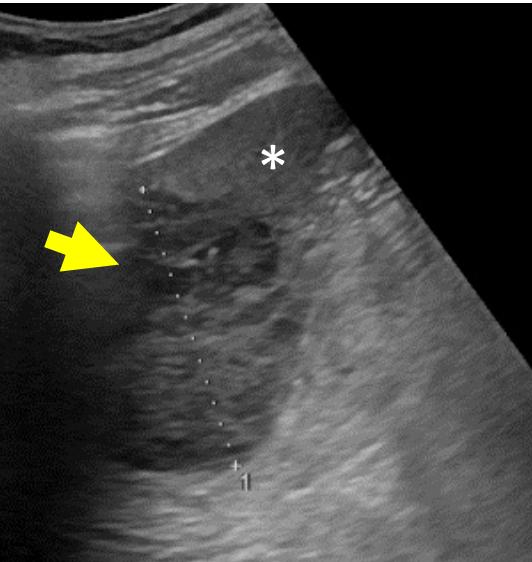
图片来源: Karlo CA, Stolzmann P, Do RK, Alkadhi H. Computed tomography of the spleen: how to interpret the hypodense lesion. *Insights Imaging* (2013) 4:65–76
